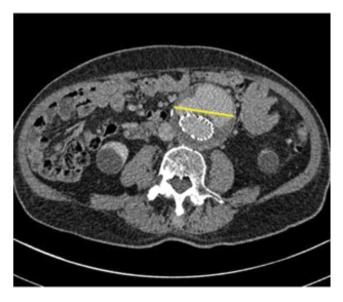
Post-EVAR CTA, delayed phase, axial plane image demonstrates measurement of endoleak diameter.
